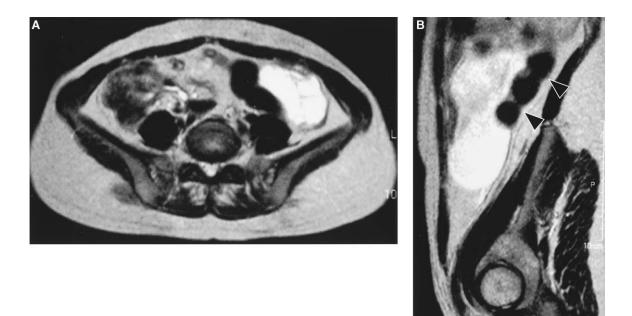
Magnetic resonance images. A, A high-intensity, multilocular cyst is evident in the left lower abdomen on T2 weighted image. B, Mass is located in the anterior portion of the descending colon. *Black arrow heads* indicate descending colon.
